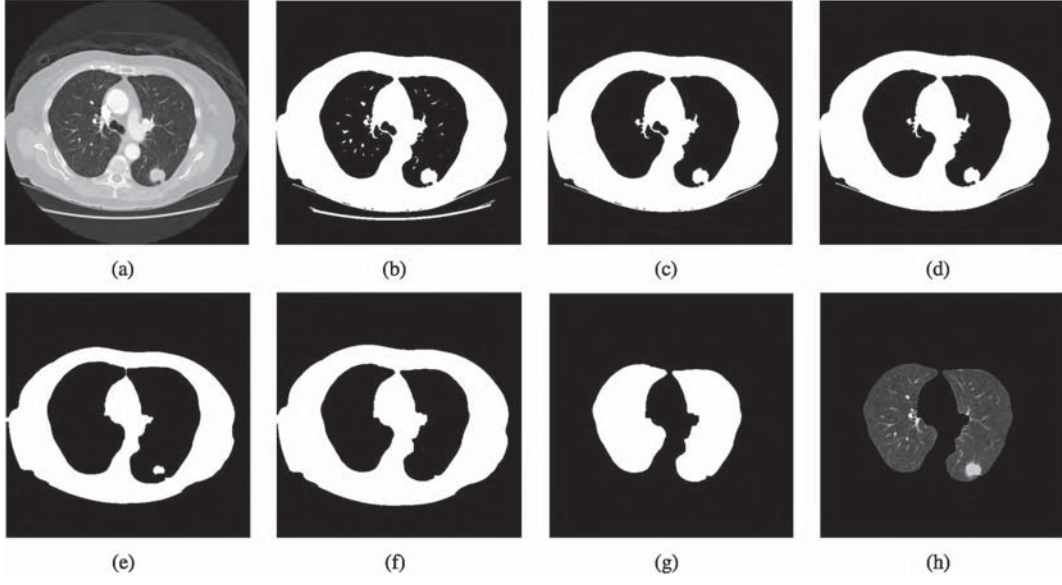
Lung parenchyma extraction steps: (a) get a raw CT slice; (b) binarize the raw CT slice by a threshold to get a binary image; (c) extract the preliminary lung outline from the binary image; (d) fill the trachea; (e) erode the outline with an operator; (f) extract the outline and dilate it with the same operator to gain the final outline; (g) get the lung parenchyma mask; (h) get the lung parenchyma.
